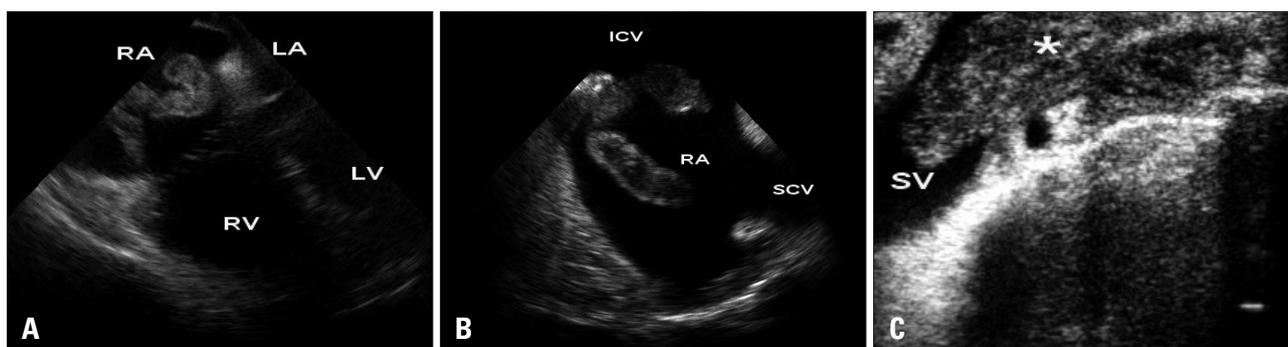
Transesophageal echocardiography (A and B) showed highly 76 mobile thrombus in the dilated right atrium, and duplex-Doppler scanning (C) revealed subocclusive thrombosis (*) of the left subclavian vein. RA: right atrium, RV: right ventricle, LA: left atrium, LV: left ventricle, SCV: superior caval vein, ICV: inferior caval vein, SV: subclavian vein.
